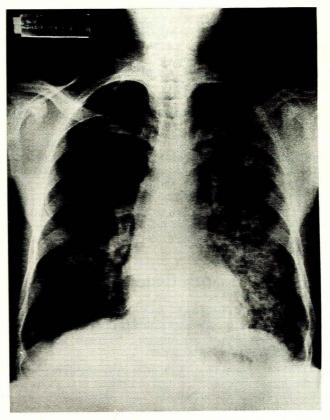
Chest X-ray film of case 1, showing a diffuse leftsided pneumonic process, with possible hilar glandular enlargement.
